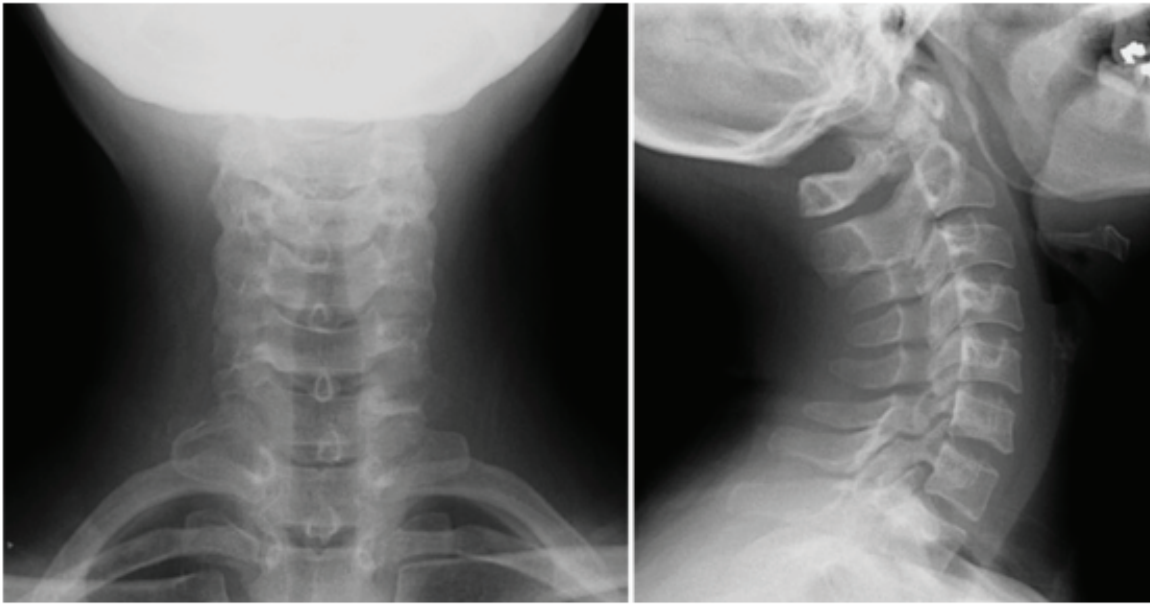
AP and Lateral View Cervical X-ray
